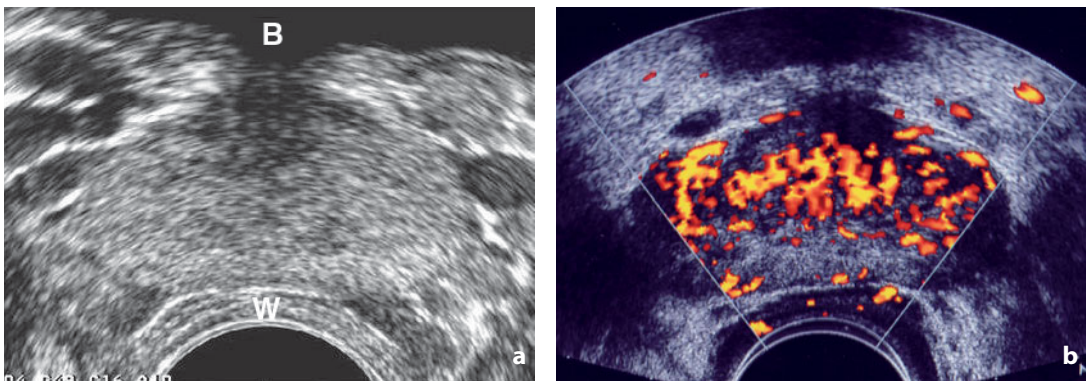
Ultrasonography. Normal prostate in a young adult. Axial scan. a The glandular structure is uniform, with no clear distinction between the central and peripheral portions. b Depiction of normal vasculature at power Doppler. *B*, urinary bladder; *W*, wall of the ampulla of the rectum
